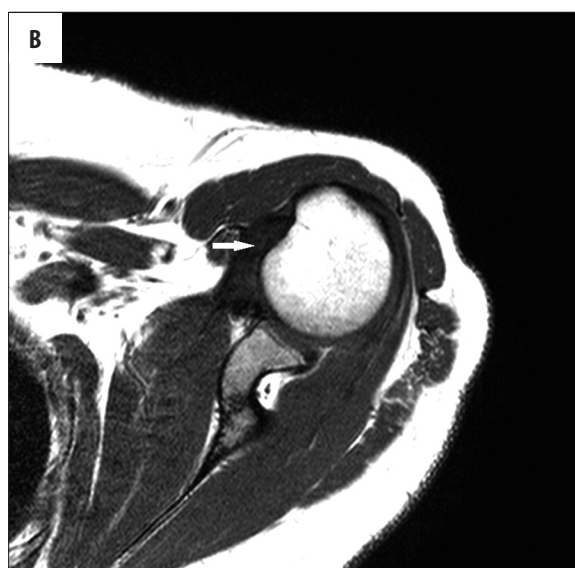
Shoulder MRI. (A) T1-weighted image, frontal plane. (B) T1-weighted image, transverse plane. Supraspinatus tendon tear (arrow) T1-weighted image, transverse plane. Subscapularis tendon tear (arrow).
